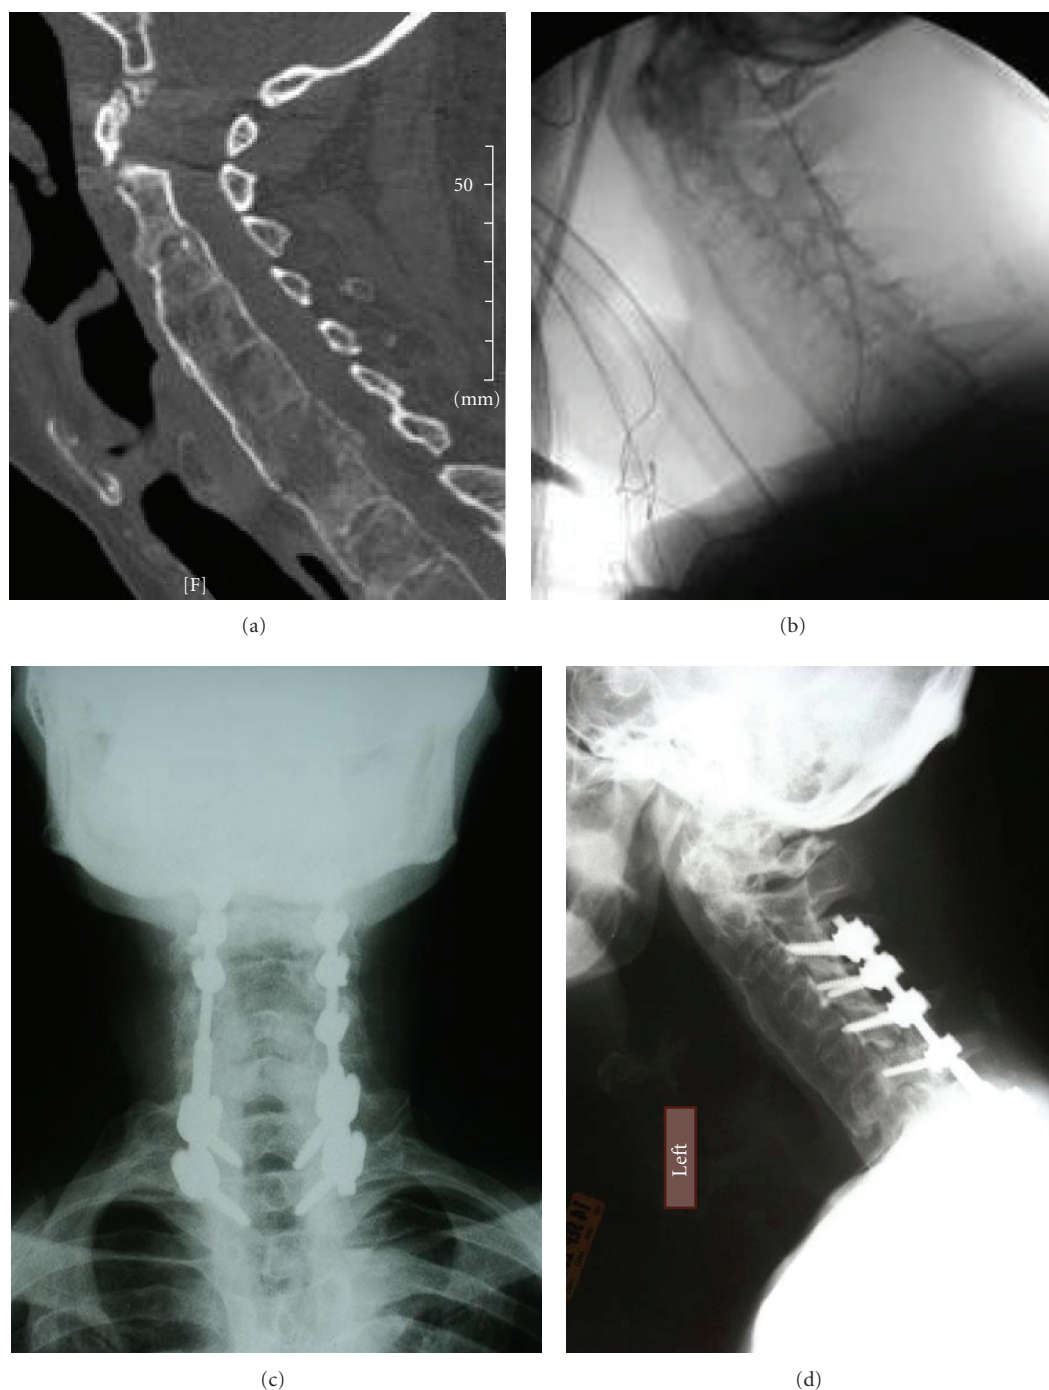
(a) Sagittal-reconstruction computed tomography demonstrating a nondisplaced shear fracture through the C6 vertebral body and C5 posterior elements. (b) Intraoperative fluoroscopy performed after the patient was positioned prone to confirm maintenance of his preexisting alignment. Postoperative anteroposterior (c) and lateral (d) X-ray demonstrating posterior C3-T2 fusion with lateral mass fixation in the cervical spine and pedicle screw fixation in the upper thoracic spine.
